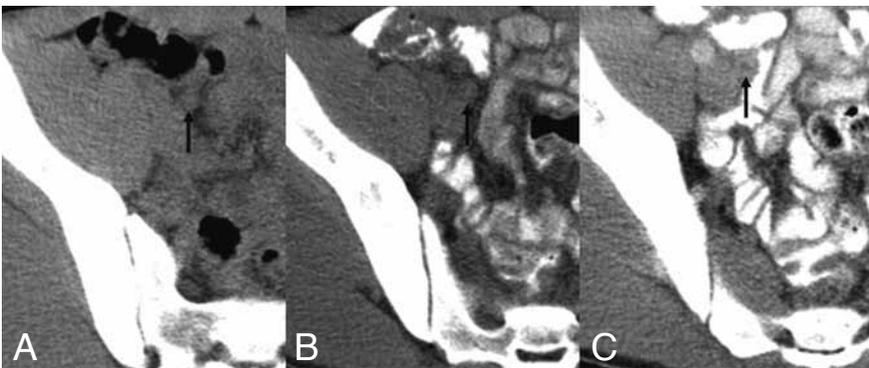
Acute appendicitis in a 17-year-old boy with little retroperitoneal fat. Unenhanced CT scan shows undefined visualization of inflamed appendix (A). With application of only oral contrast, the appendix is more defined (B). Finally, with oral and IV contrast administration inflamed appendix (arrow) is seen clearly on axial scan (C).
